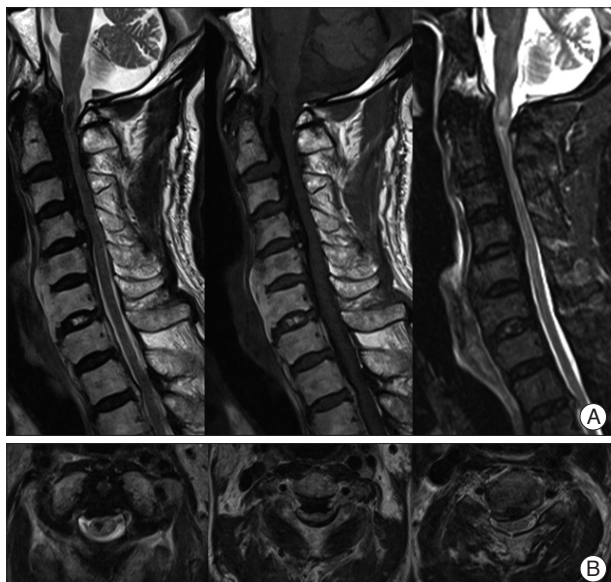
Preoperative cervical MRI. A : Sagittal cervical MRI revealing thick diffuse OPLL with cord compression and heterogeneous signal change from the cervicomedullary junction to the C4 level. B : Also, axial MRI reveals right side dominant spinal cord compression and signal change of the spinal cord. MRI : magnetic resonance imaging, OPLL : ossification of the posterior longitudinal ligament.
